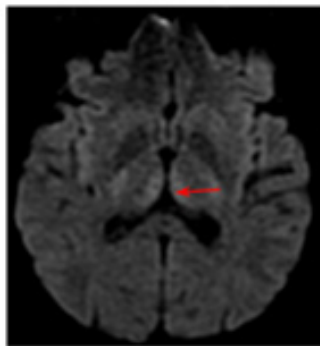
Cerebral MRI images showing hyperintense signal of the periaqueductal gray matter.
